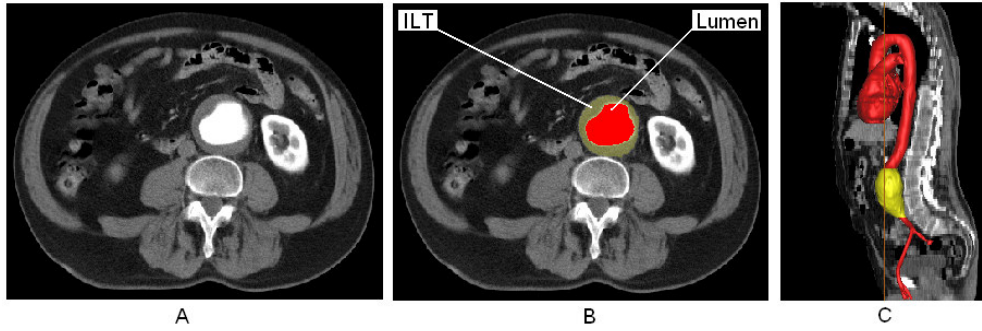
(A) Typical CT scan showing aneurysmal aorta in centre of image, (B) algorithm defines regions of interest and (C) software generates 3D reconstruction of desired regions.
